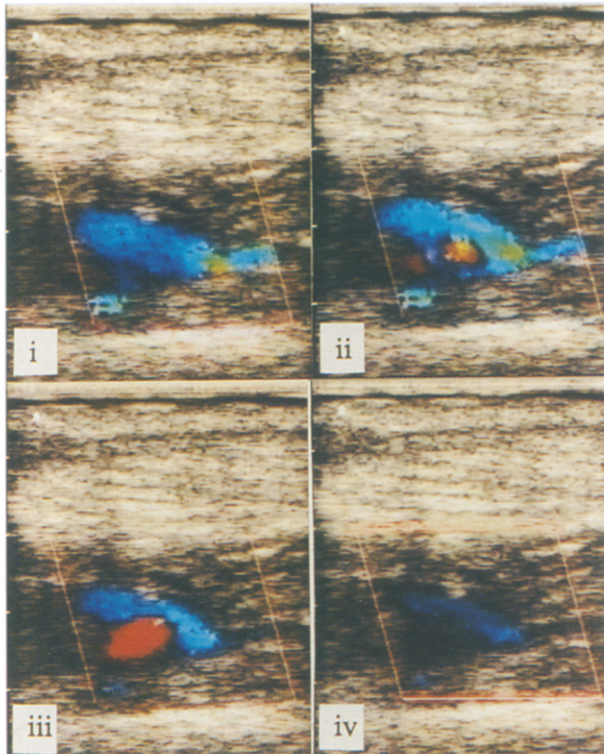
Snapshots of the colour Doppler images of the Miller cuff anastomosis, captured at four intervals during the cardiac cycle (frames i-iv).
